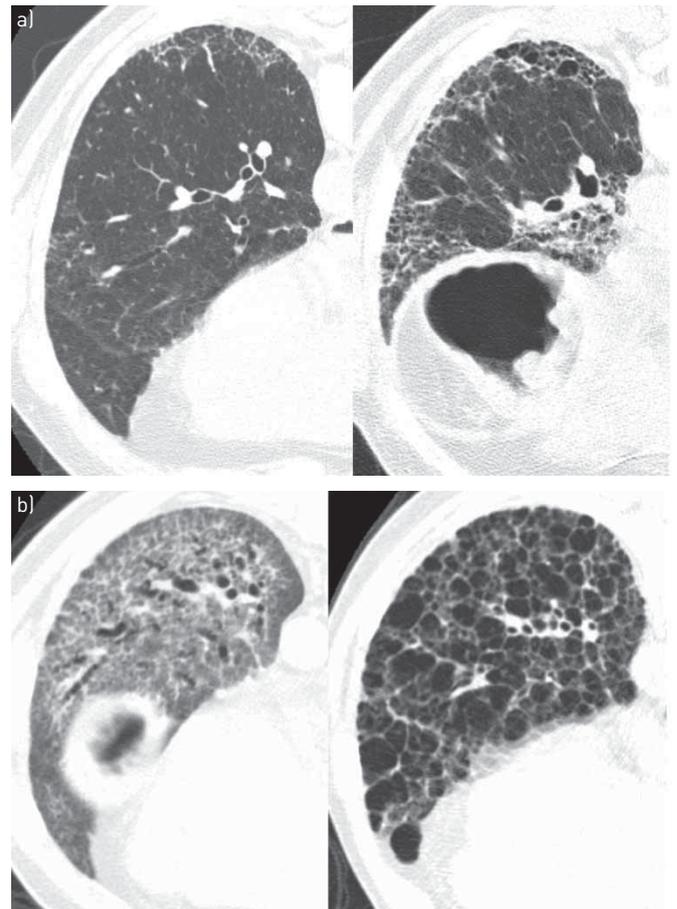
Changes in high-resolution computed tomography (HRCT) pattern over time. a) Idiopathic pulmonary fibrosis (IPF), increased specificity over time. Initial HRCT in a patient with early IPF (left) shows mild subpleural reticulation without honeycombing. 3 years later (right) honeycombing has developed. While the initial study is nonspecific, the follow-up HRCT would be considered a “definite usual interstitial pneumonia” pattern and diagnostic of IPF in the appropriate clinical setting. b) Nonspecific interstitial pneumonia (NSIP), change in pattern over time. Baseline prone HRCT image (left) in a patient with rheumatoid arthritis demonstrates reticulation and traction bronchiectasis with subpleural sparing compatible with NSIP. 8 years later (right) there is diffuse honeycombing that would be compatible with a usual interstitial pneumonia pattern.
